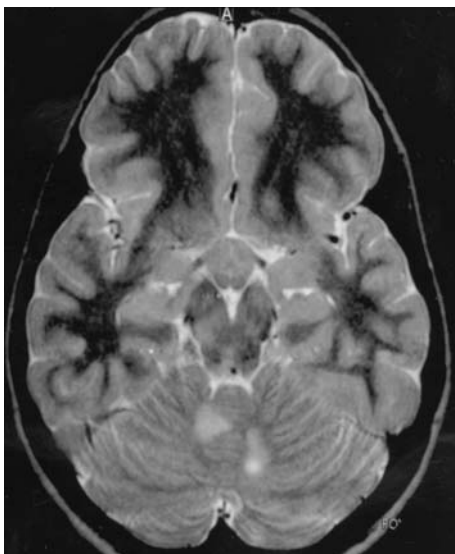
T2-weighted FSE MRI of an 11-year-old girl with precocious puberty and NF1. MRI shows hypothalamic glioma and multiple “UBOs” in brainstem and cerebellum
